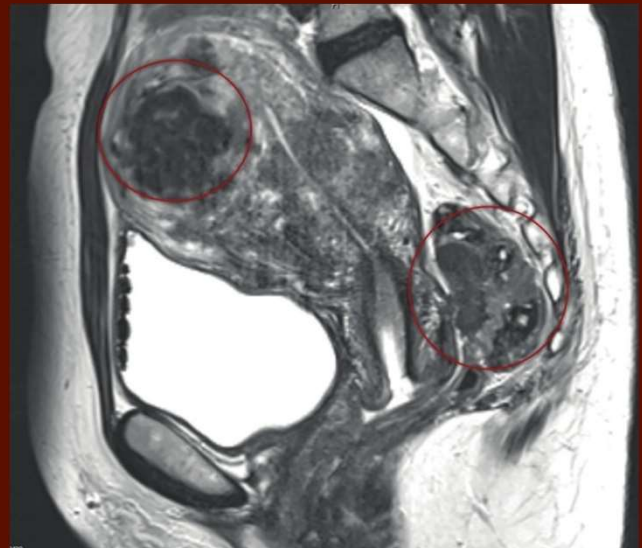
MRI with DE on the rectum with adhesions to the posterior cervix and adenomyosis
